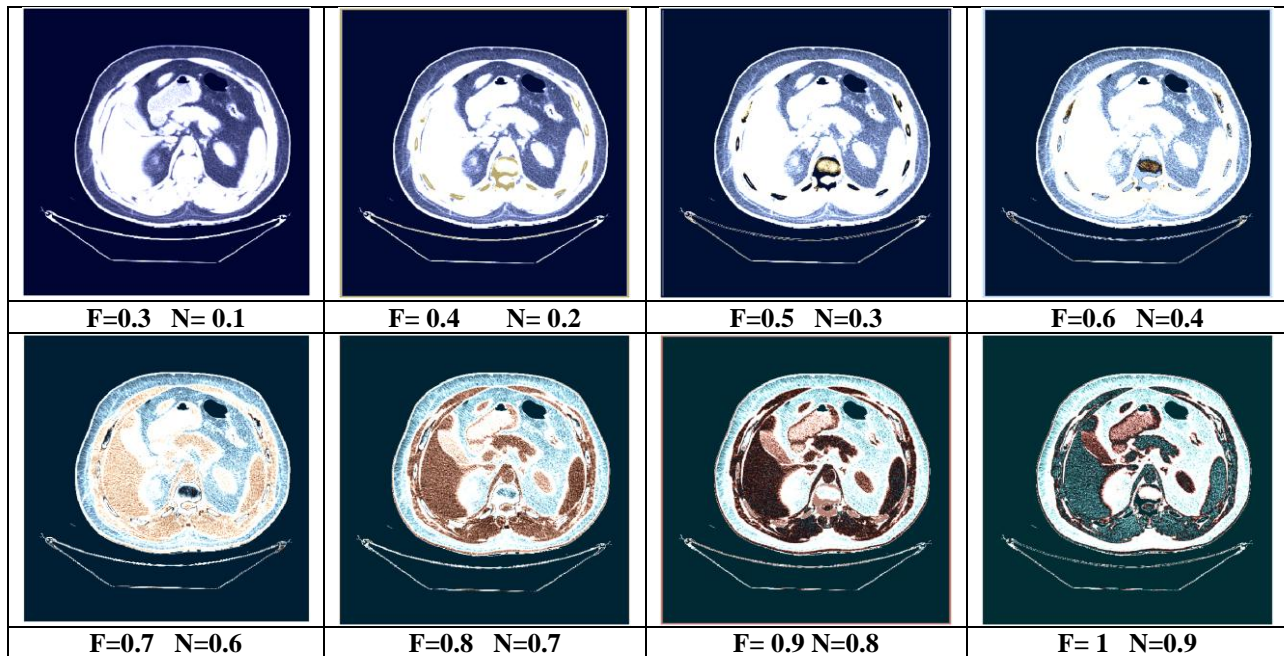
The color output CT-Scan images with different F, N value
